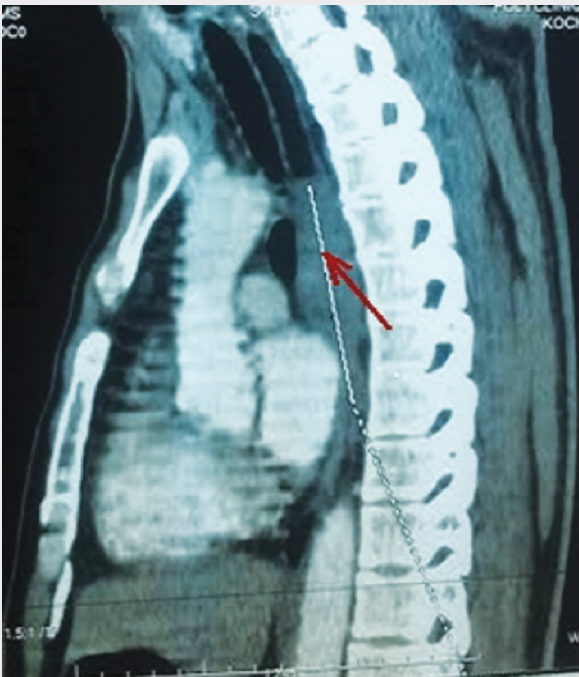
A longitudinal section of contrast enhanced CT scan showing a tissue lesion of visceral mediastinum (red arrow), in contact with the descending thoracic aorta, the posterior wall of the left main bronchus and the carina without signs of infiltration.
